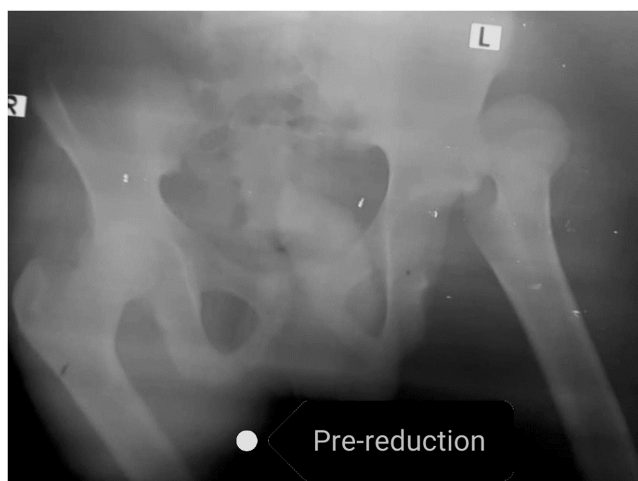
Pelvic X-RAY revealed bilateral hip dislocation, without associated fracture of the pelvis, acetabulum, or femur.
